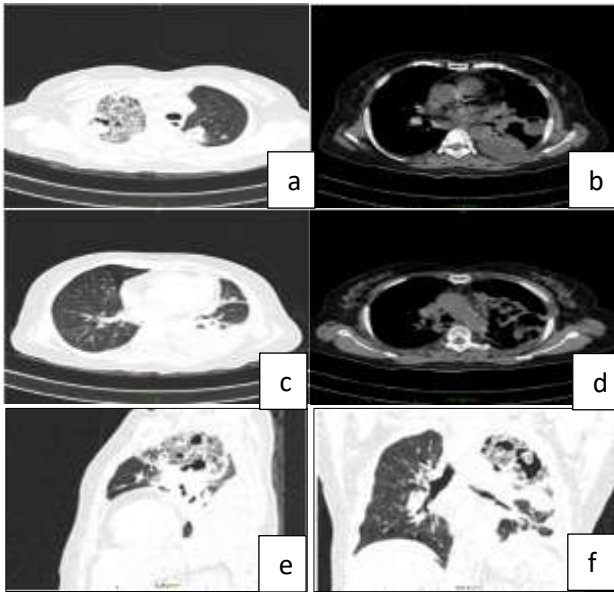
(a-f): CT images showing reverse halo sign.
